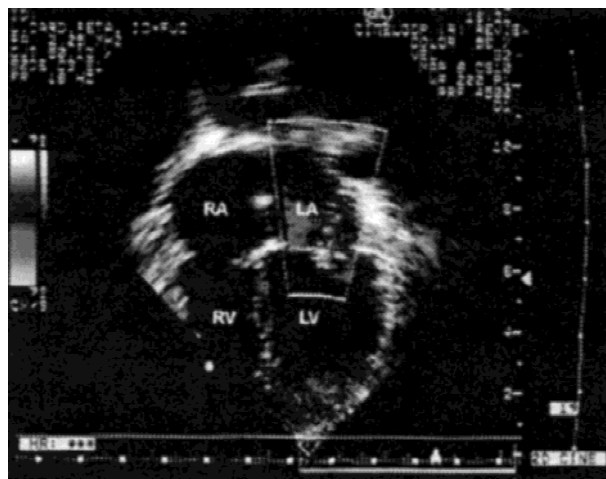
Apical four-chamber view shows mild postoperative mitral regurgitation. LA, left artery; LV, left ventricle; RA, right artery; RV, right ventricle.
